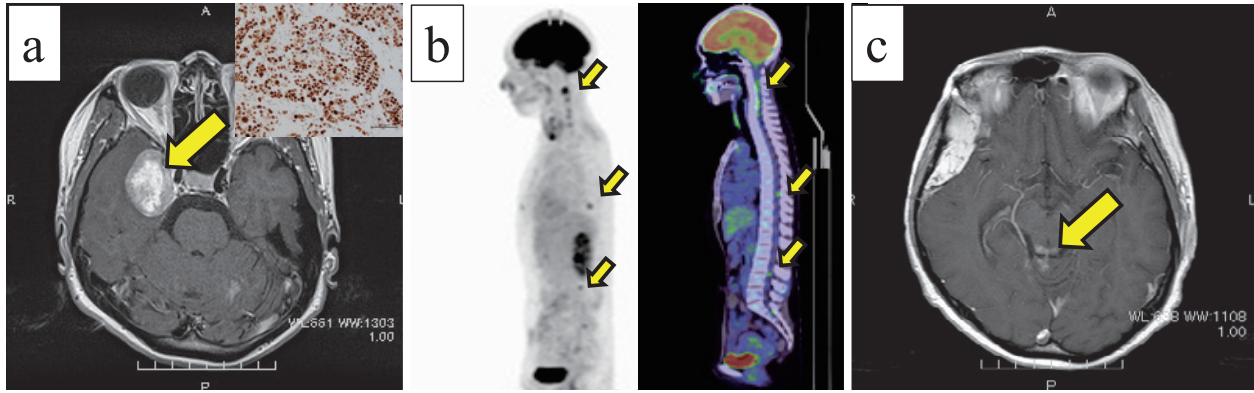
Immunoreactivities of p53 (brown precipitate), MRI, and FDG-PET. (a) brain metastasis, (b) FDG-PET image of carcinomatous meningitis, and (c) MRI of meningeitis carcinomatosa.
